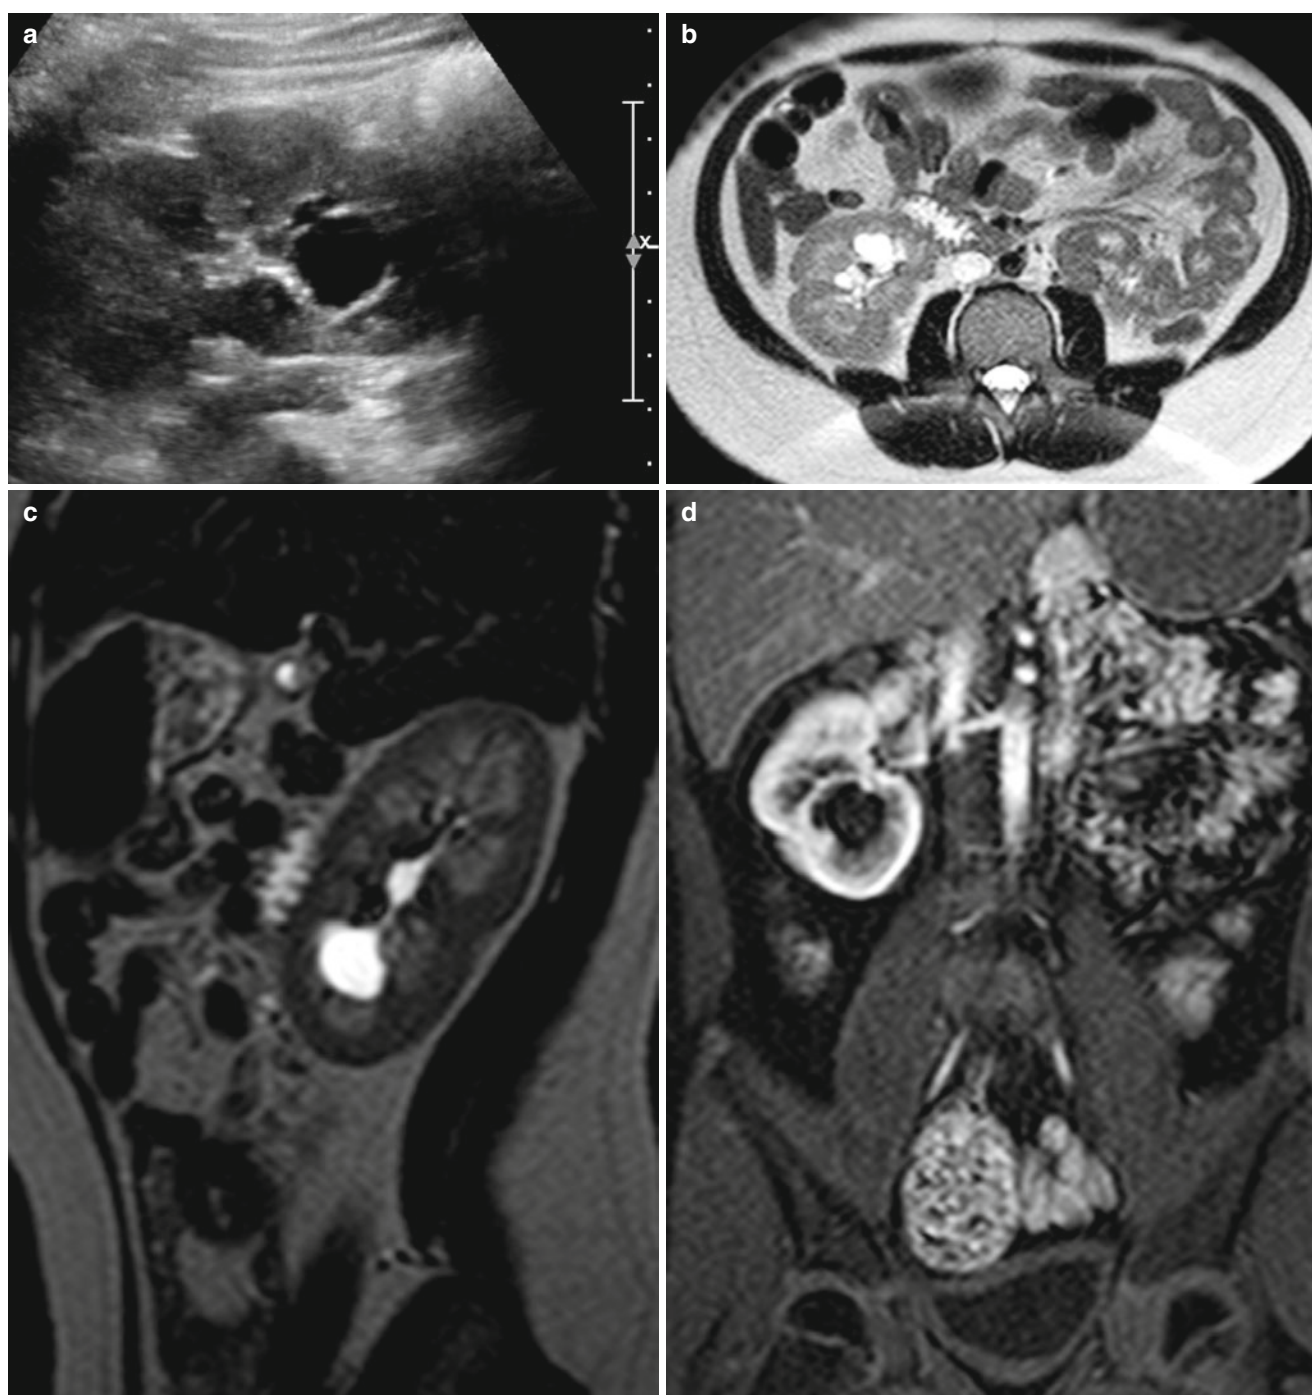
Calyceal diverticulum in a 10-year-old boy.* (a) Abdominal US of right kidney shows multilobulated cystic lesion in the medullary portion of lower pole. (b) T2-weighted axial MR image also shows multilobulated cystic lesion in right kidney lower pole. (c) T2-weighted sagittal MR image of right kidney demonstrates the connection between
